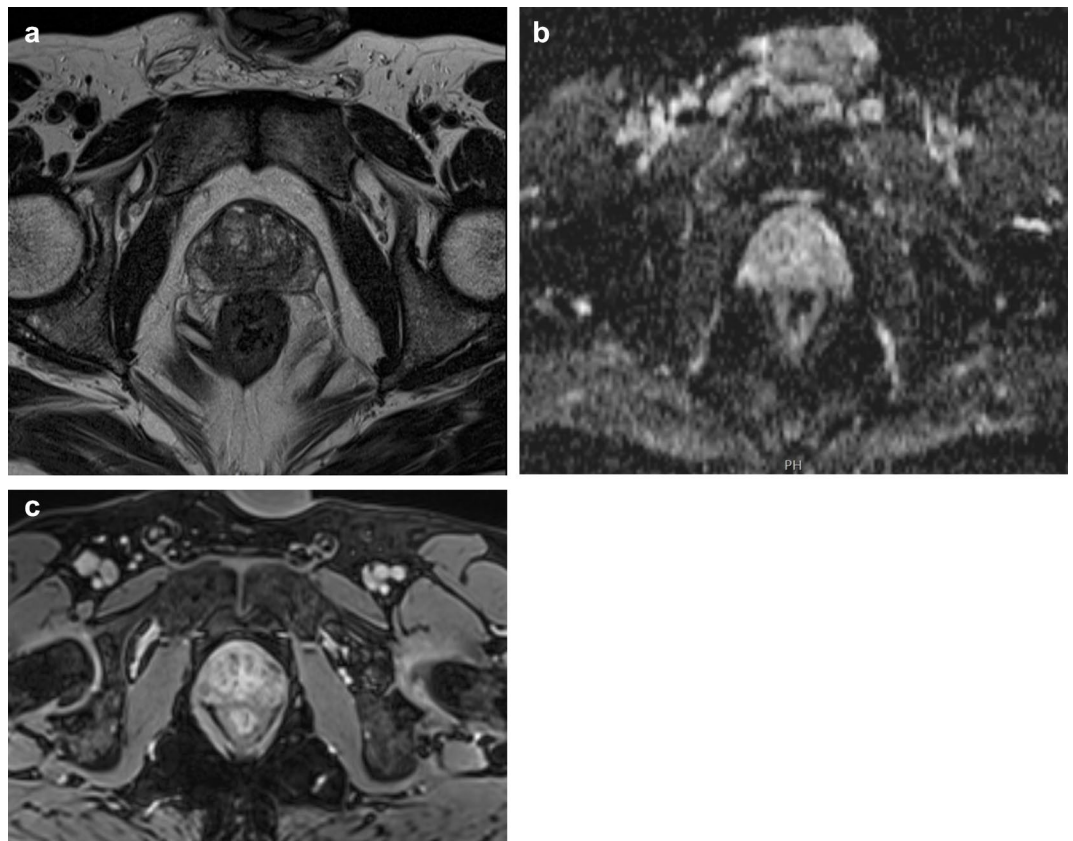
A 62-year-old man who underwent multi-parametric prostate MRI at 1.5 T. (a) On the axial T2-weighted image, there is prominent noise with a relatively low signal-to-noise ratio. Anatomical structures are mostly delineated, and no artifacts are present; however, the signal-to-noise ratio remains low on both coronal and sagittal T2 W images (not shown). (b) The anatomically matched axial apparent diffusion coefficient (ADC) map is free of artifacts, but the contrast and signal-to-noise ratio are relatively low, though delineation of the peripheral and transitional zones is possible. (c) Vessels are clearly delineated, with no visible artifacts on the dynamic-contrast-enhanced image. Reader 1, 4, and 5 assigned a Prostate Imaging Quality (PI-QUAL) V2 score of 2, while reader 2 and 3 assigned a PI-QUAL V2 score of 1 for this case. For PI-QUAL V1, reader 1 and 4 assigned a score of 4, reader 2 and 5 assigned a score of 3, and reader 3 assigned a score of 2.
